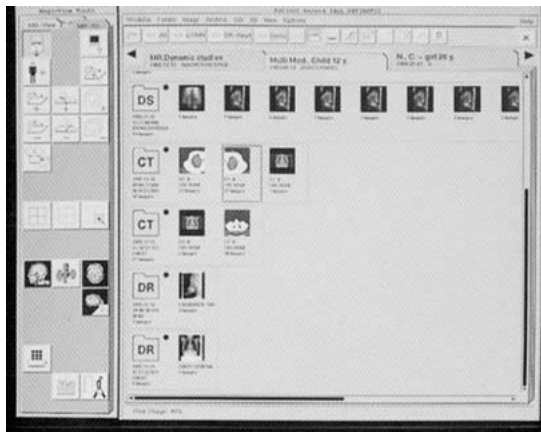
The patient folder with old images and radiographic reports retrieved for diagnosis work.
